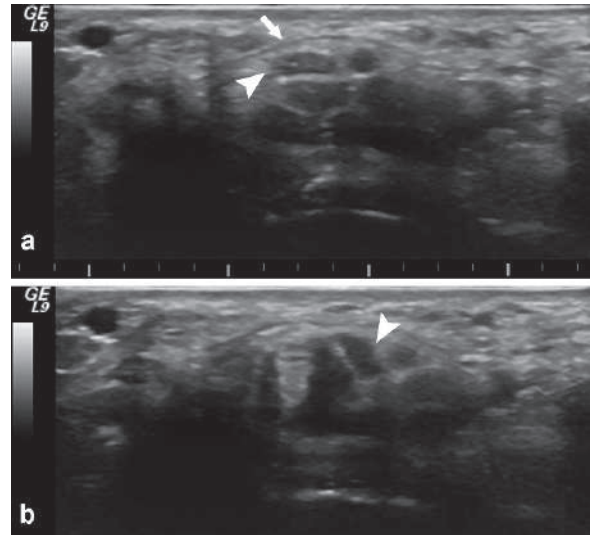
Median nerve ultrasound in a healthy volunteer shows the normal median nerve (*arrowhead*) seen below the flexor retinaculum (*arrow*) as a hypoechoic structure in (a) and (b). The median nerve transverse diameter was 4 mm. In the flexion pinch maneuver, the patient is asked to flex his wrist, forcefully oppose the thumb to the index finger, hold the position for 3–5 s, and then release. In this maneuver, the median nerve moves in a sagittal motion deep into the carpal tunnel (*arrowhead* in b), and then returns to its normal position. Failure of the nerve to return to its normal position or to move deep into the carpal tunnel with this maneuver is a sign of entrapment
